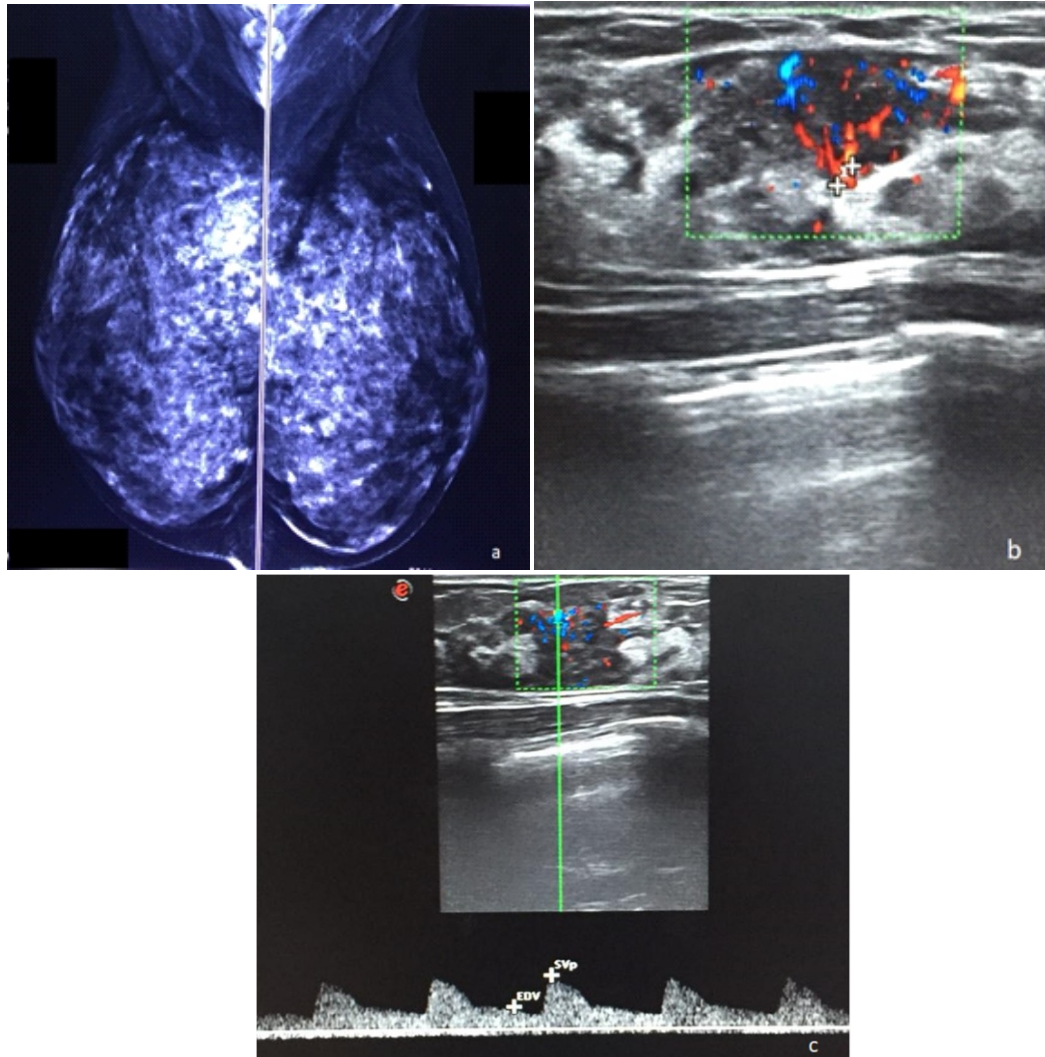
A 37-year-old woman with extremely dense breast tissue and an invasive ductal carcinoma in her right breast. a) Mediolateral mammography of both breasts shows a dense irregular mass in the right breast deep upper area. b) Color Doppler image of the same mass shows an irregular mass with a significant flow in the entire mass. c) Spectral color Doppler of the mass and the peak systolic and end diastolic flow measurements.
